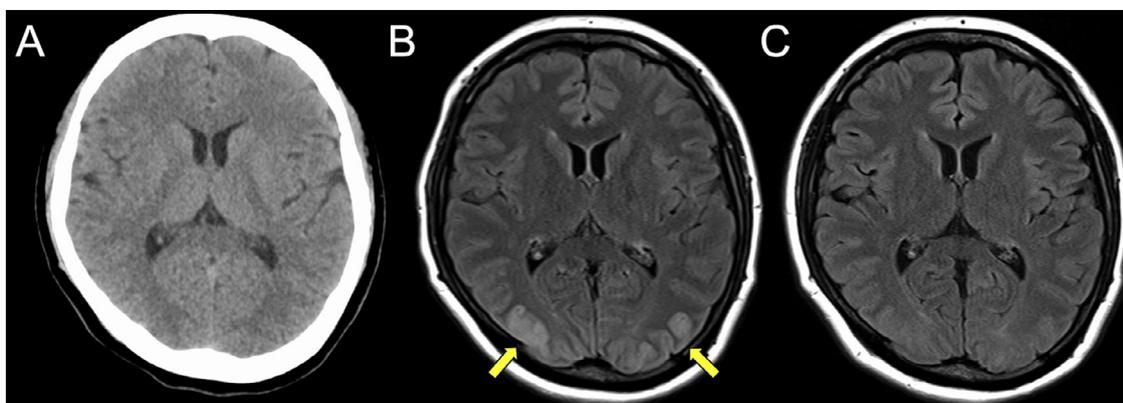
A head computed tomography scan obtained 6 hours after surgery showed no significant findings (A). T2-weighted magnetic resonance imaging of the head obtained 6 hours after surgery revealed multiple areas of high signal intensity with cortical and subcortical predominance in the bilateral parietal to occipital lobes (yellow arrow) (B). Follow-up head magnetic resonance imaging 6 days after surgery showed the improvement of the occipital lobe lesions (C).
